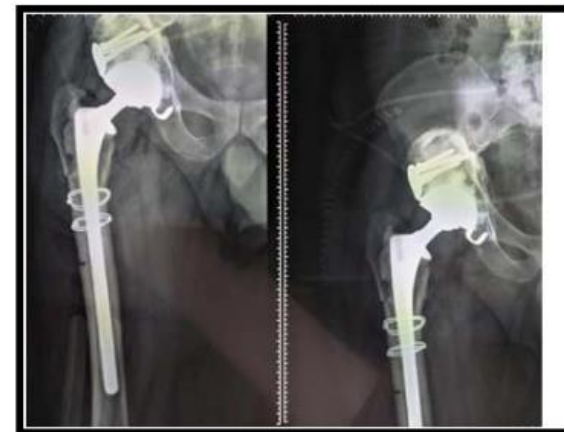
Post-allograft control pelvis radiograph
